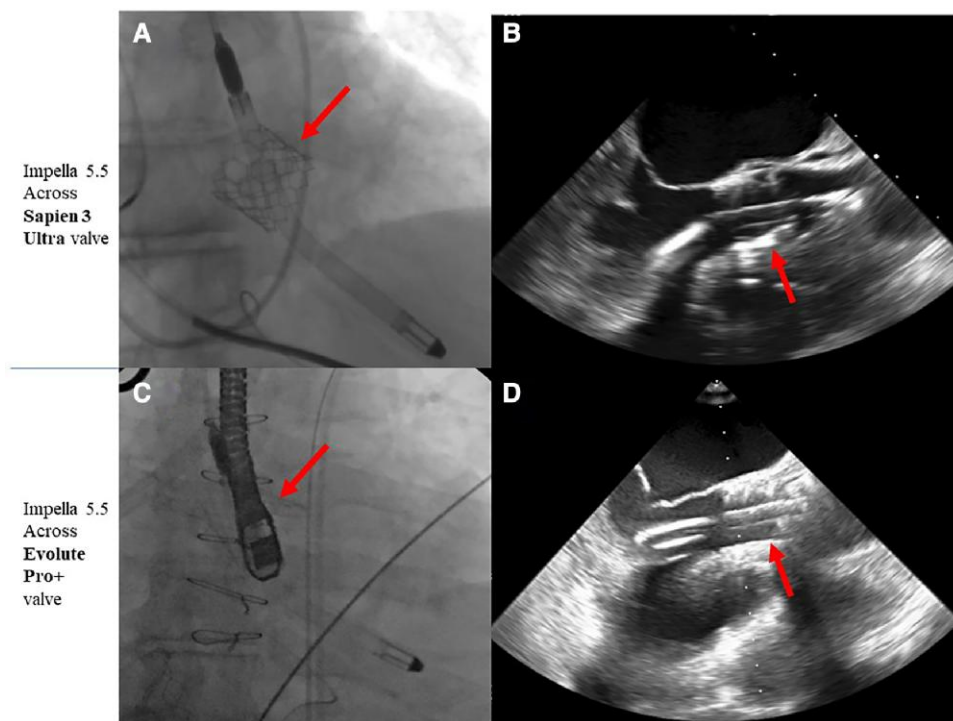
Fluoroscopic and echocardiographic images of Impella 5.5 placed through transcatheter aortic valve. (A) Fluoroscopic image and (B) echocardiographic image of Impella 5.5 implanted through 26 mm Sapien 3 Ultra valve. (C) Fluoroscopic image and (D) echocardiographic image of Impella 5.5 implanted through 34 mm Evolute Pro + valve.
